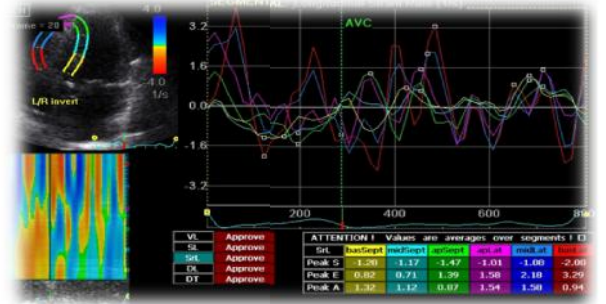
Right ventricular (septal and free walls) peak longitudinal systolic strain (S%) by two dimensional speckle tracking in a healthy subjects in apical four chamber view
